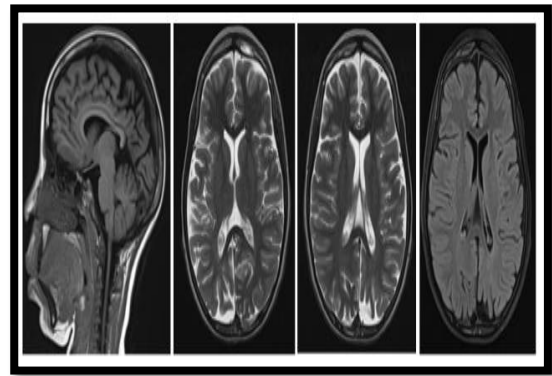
MRI angiogram showing widening of subarachnoid spaces and cortical sulci, as well as bilateral leptomeningeal enhancement
